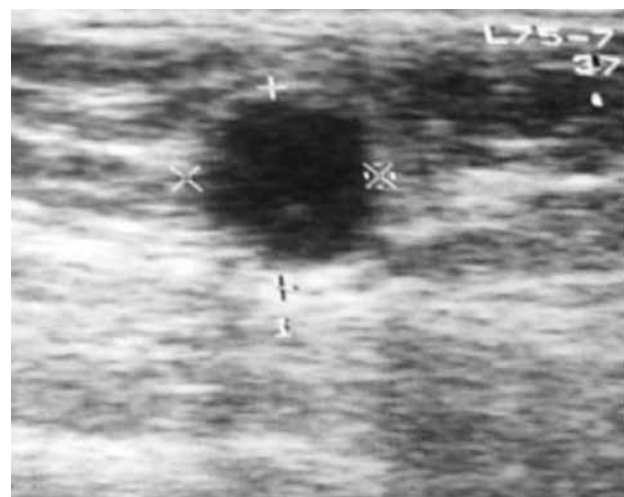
Ultrasound scan of the breast nodule revealed a homogeneous hypoechoic nodule 2 x 2 cm in size.
